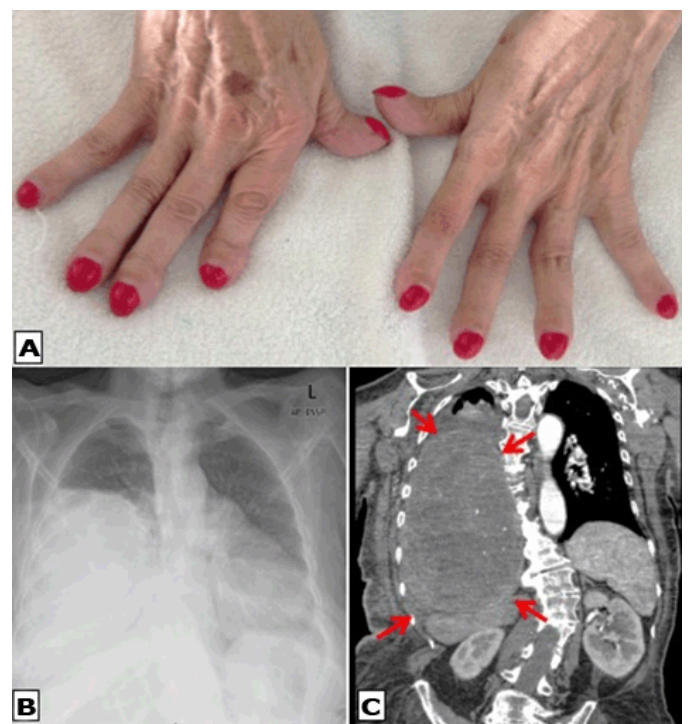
(A) Digital clubbing, (B) Anteroposterior chest radiograph image demonstrates a right hemithorax opacification with contralateral mediastinal shift, (C) Coronal volume-rendered CT image showing a 17.4x14x19.5 cm heterogeneous mass in the right hemithorax, with areas of necrosis.
